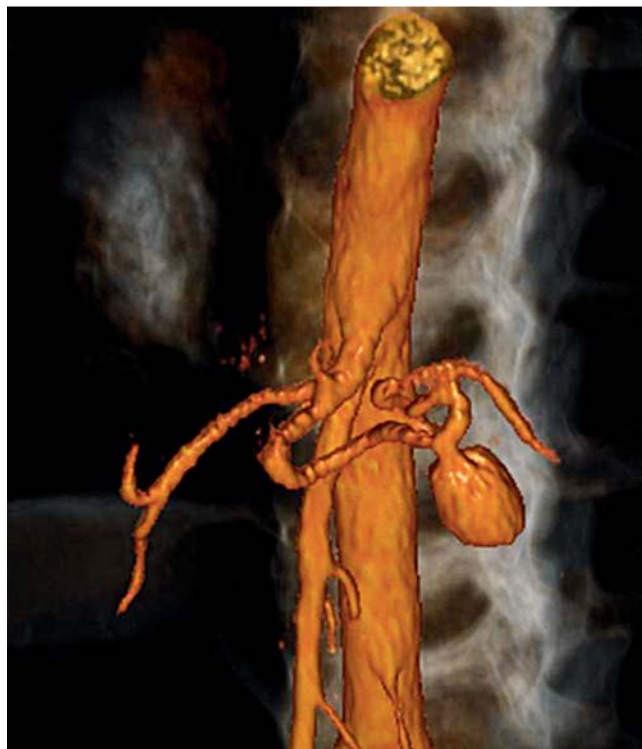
Three-dimensional (3D) computed tomography (CT) angiogram showing the pseudoaneurysm of the splenic artery.
